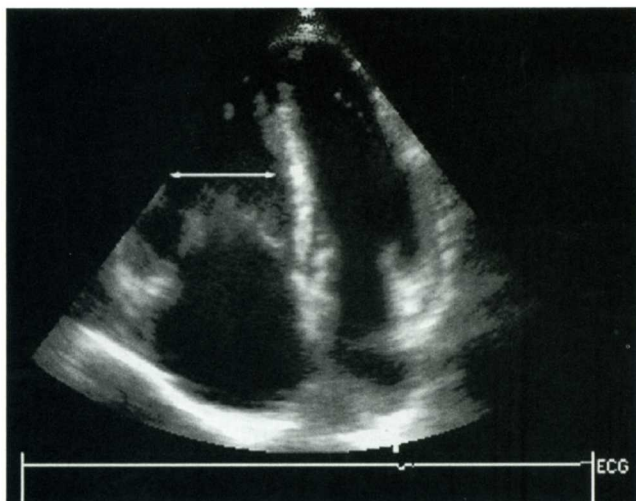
RV enlargement. Apical four-chamber transverse diameter exceeds 2.5 cm.
